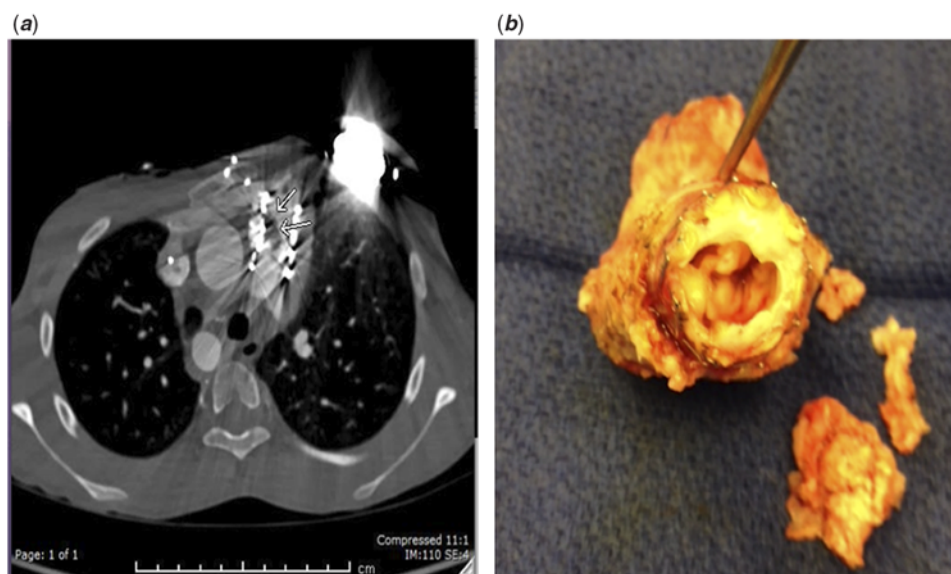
(a) Case 1 – CTA showing a filling defect along the superior and right side of the valve measuring 1.6×0.7 cm. (b) Case 1 – Image of the Melody valve[®] with vegetation removed during surgery. CTA=CT angiogram.
